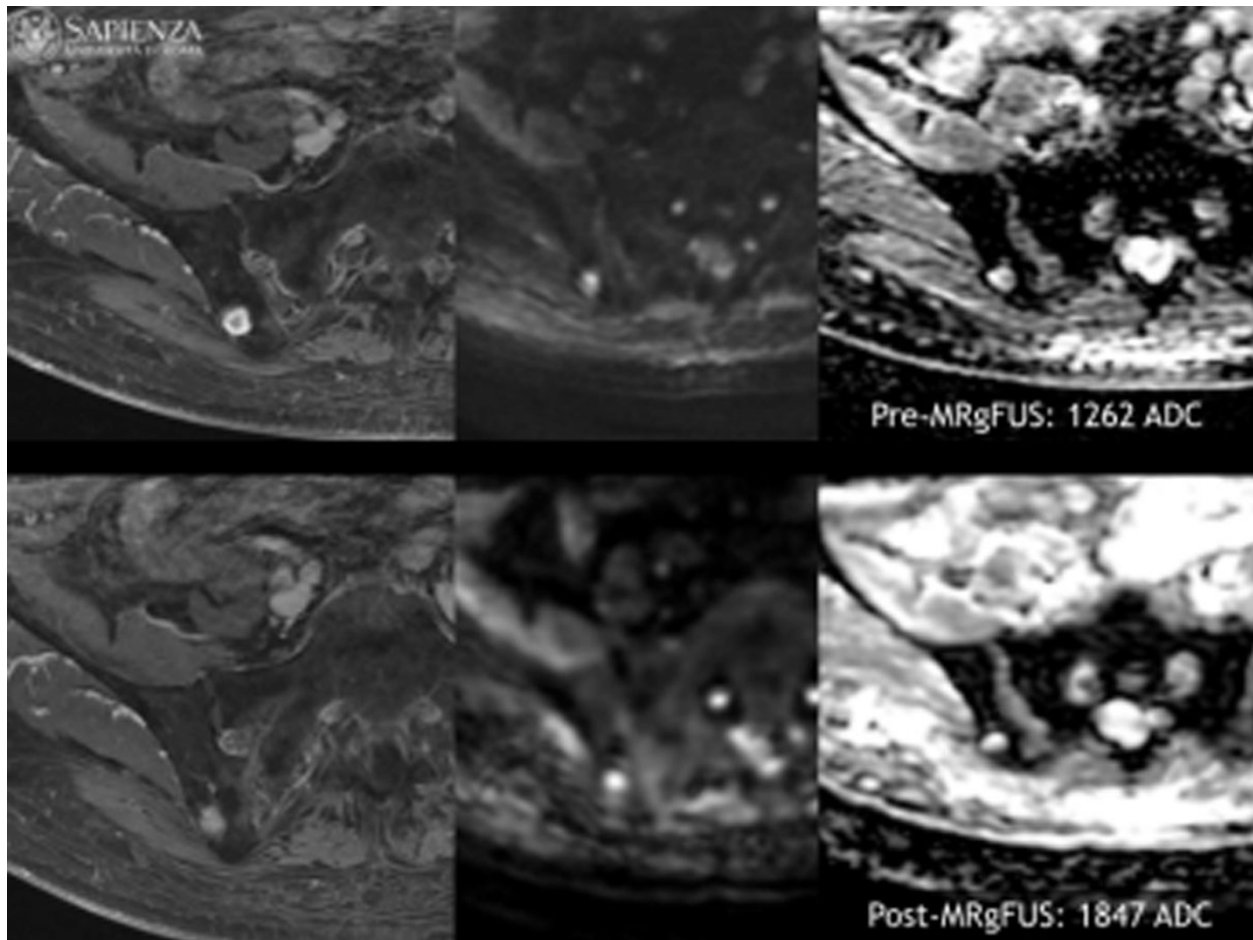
70 years old patient with renal cell carcinoma. Same as figure 1, it has been verified an increase ADC value after MR guided ultrasound treatment (ADC baseline: 1262 mm²/s. ADC 3 months: 1847 mm²/s). At 3 months follow-up VAS value 4 (VAS baseline 8).
